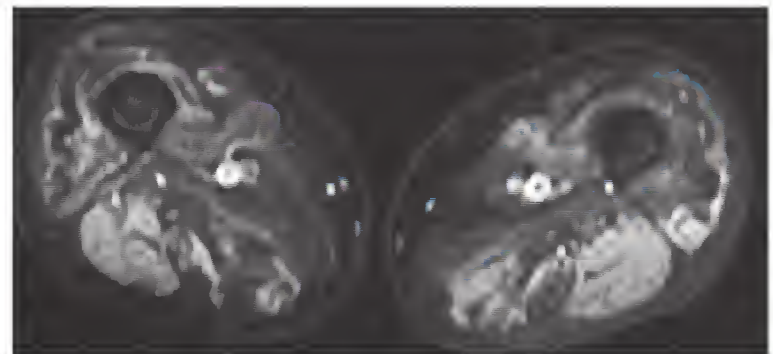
Magnetic resonance images of the thigh. In cross section using the short tau inversion recovery technique, atrophy of the anterior muscles is evident. Inflammation shows up as bright areas in the posterior muscles. (Courtesy Dr. J. Frank and Dr. D. Fraser.)
